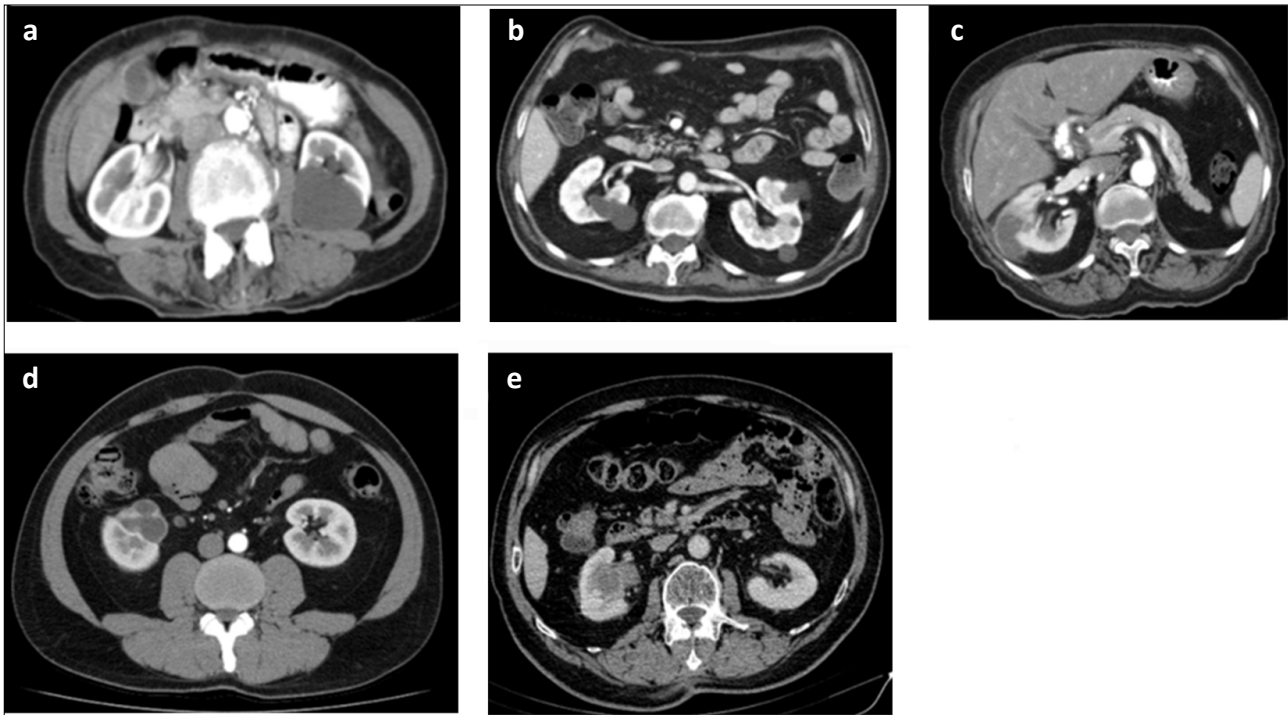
Representative computed tomography images from the dataset used for evaluation, showing an example for each subtype of the Bosniak classification: Bosniak Type I (a), Type II (b), Type III (c), Type III (d), and Type IV (e).
